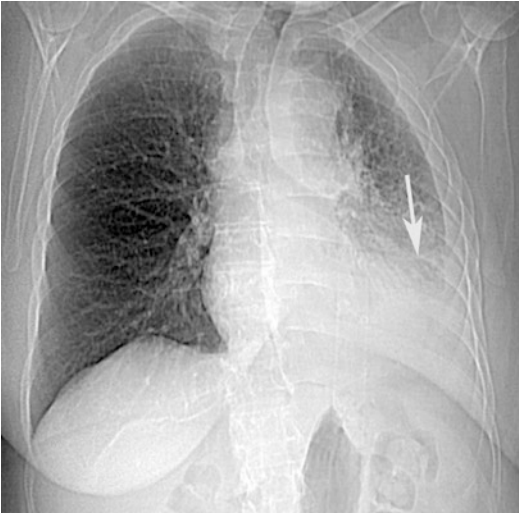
Posteroanterior chest radiograph shows dense left lower lobe airspace consolidation (*arrow*) with pleural fluid
